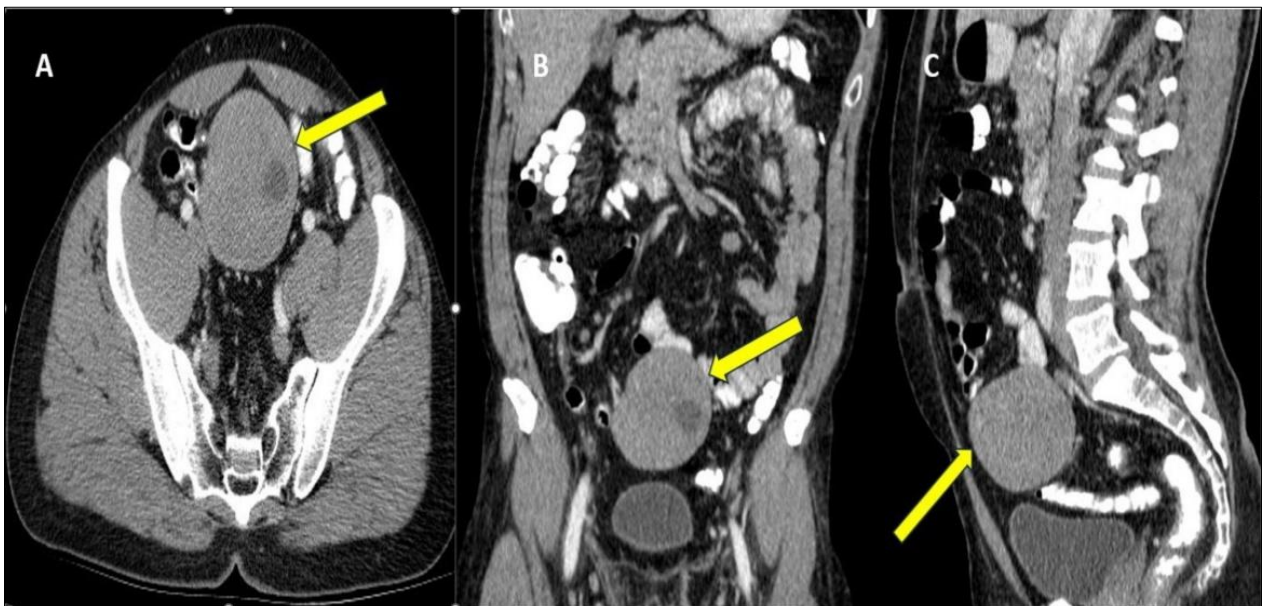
Contrast-enhanced CT scan. Axial (A), coronal (B), and sagittal (C) images show a well-defined enhancing mass lesion noted intraperitoneally in the lower abdomen which is marked with a yellow arrow
